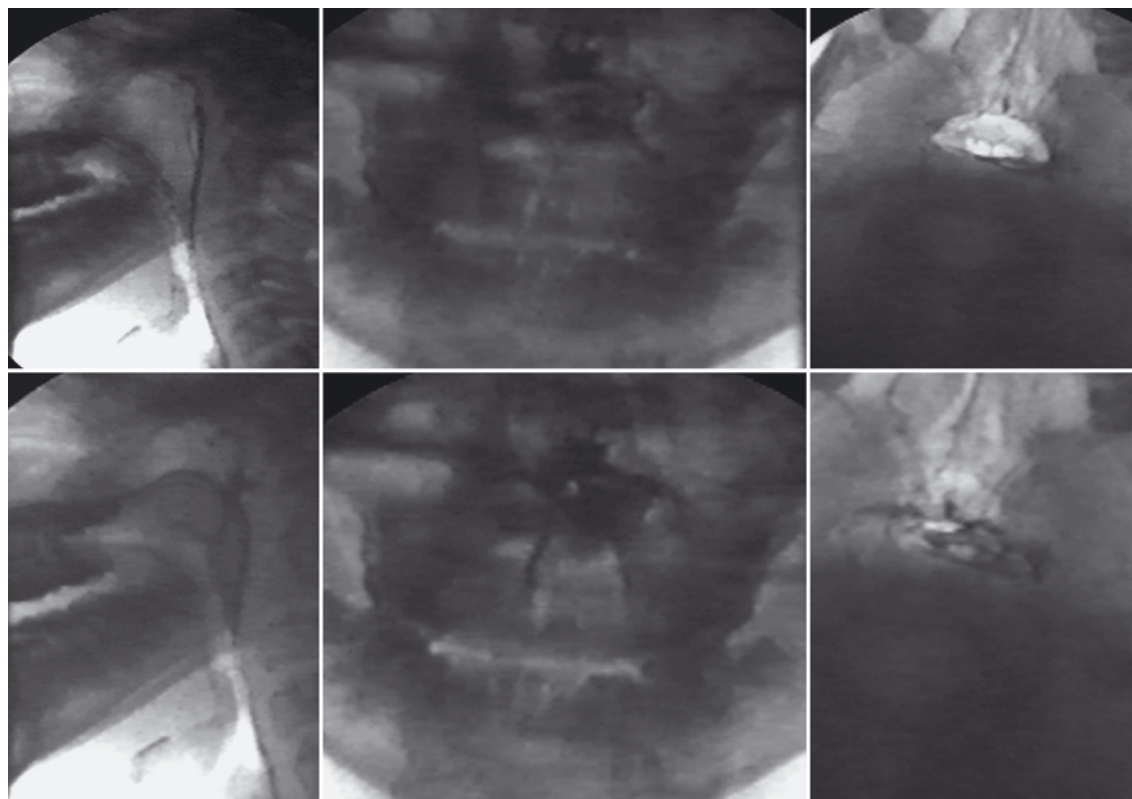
Lateral, frontal, and base radiographic views at rest and during speech in an individual with a repaired cleft and hypernasal speech
